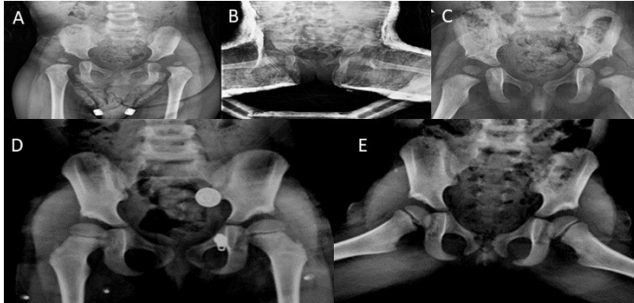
16 month old female patient preoperative AP radiography (A) Postoperative AP radiography after bilateral Ludloff medial approach technique (B) Postoperative 3rd month AP radiography (C) Postoperative 28 month AP (D) and frog leg (E) radiography
